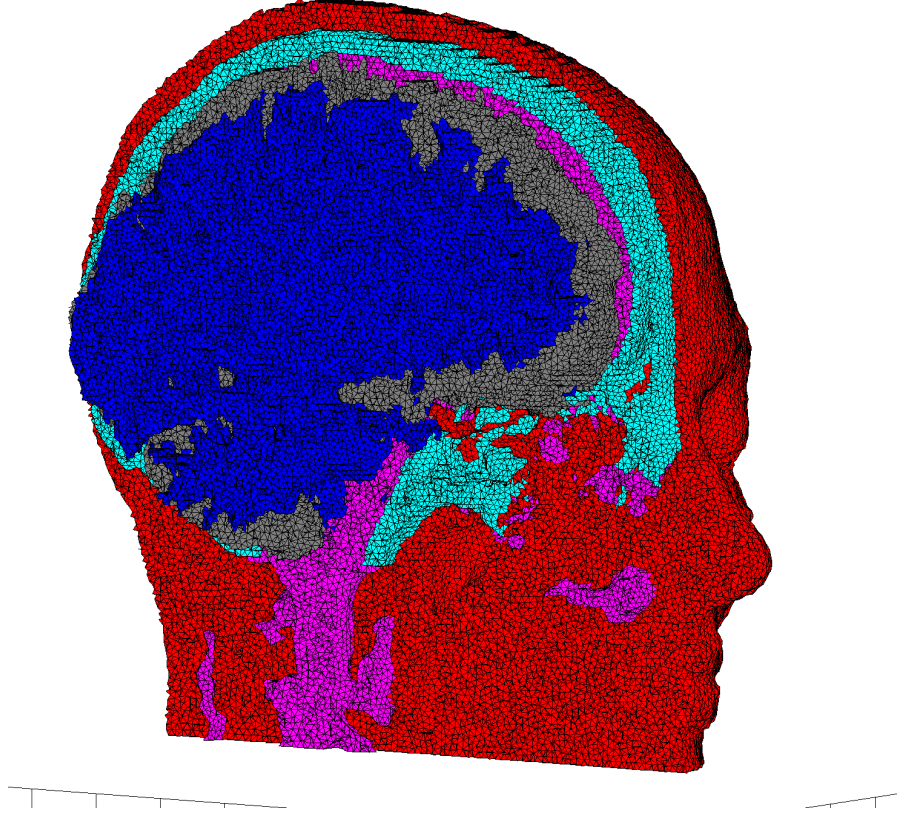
Layered cut through a 5 million element head mesh - The mesh was created with CGAL from a segmentation of a CT and an MRI scan of the same person and contains the following tissues: scalp, skull, cerebro-spinal fluid, grey and white matter, and also parts of the superior sagittal sinus and air cavities, which are not visible in this image.
